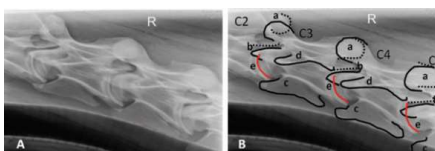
[052]: oblique radiograph (left lateral 45-50° dorsal to right lateral-ventral oblique) of cervical vertebrae 3 and 4: a = right APJs (dashed line = caudal articular processes, solid line = cranial articular processes), b = left APJs (dashed line = caudal articular processes, solid line = cranial articular processes), c = left transverse processes, d = right transverse processes, e = IVD space
